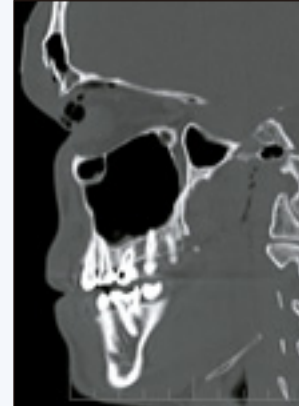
Sagittal CT image of patient with right supraorbital rim fracture and concomitant fracture of the anterior table of the frontal sinus.
